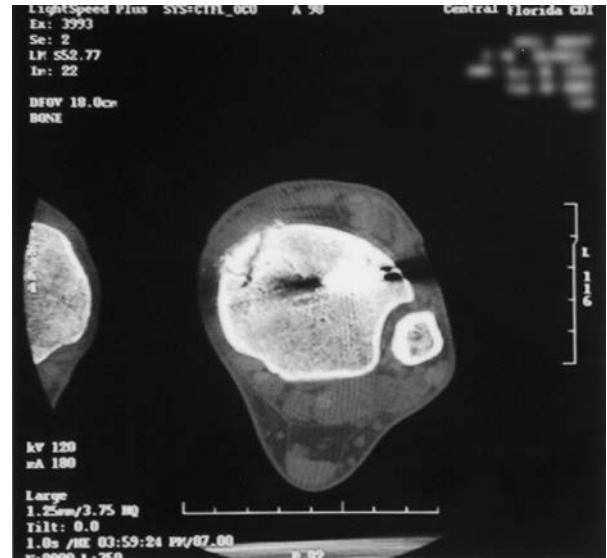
Axial computed tomography (CT) scan showing stress fracture of the antero-medial tibial plafond.
